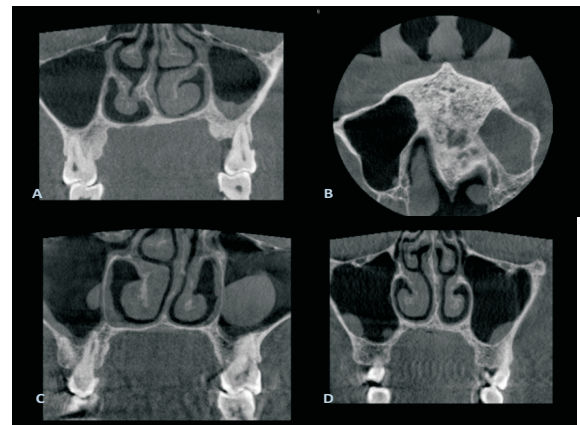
CBCT images showing A) Sinus mucosa thickening B) Opacification C) Polyp D) Retention pseudocyst
